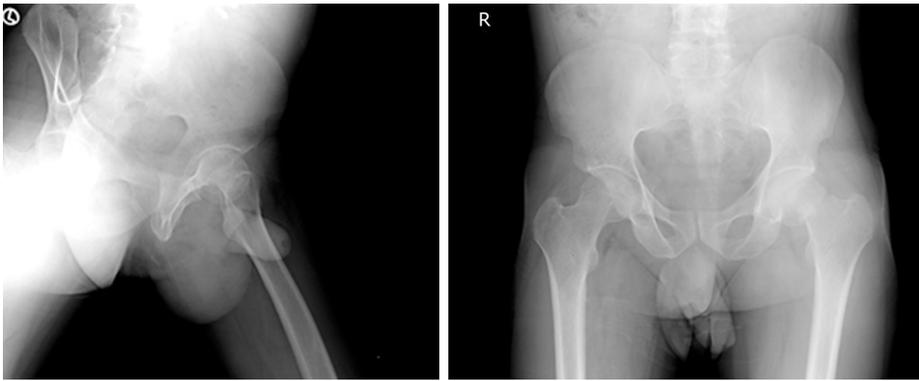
Preoperative anteroposterior and lateral X-rays demonstrating transcervical stress fracture of left femoral neck, with Singh's grade III osteopenia noted on the right proximal femur.
